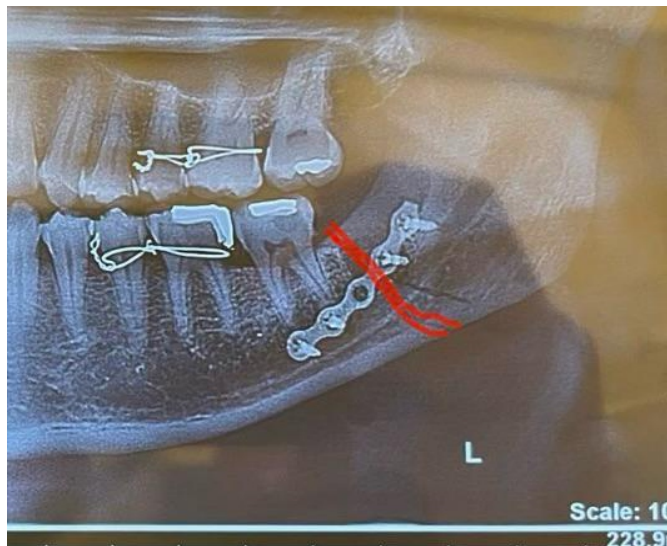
Postoperative Panoramic Radiograph (Orthopantomogram)
